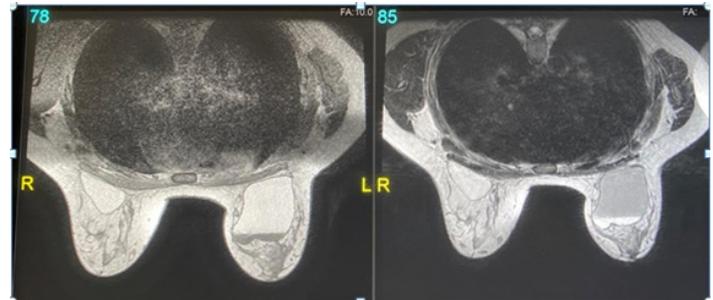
MRI-Axial T1 and T2 WI showing fluid filled lesion in both breasts showing fat signal. And in the left breast, there is fat-fluid level
